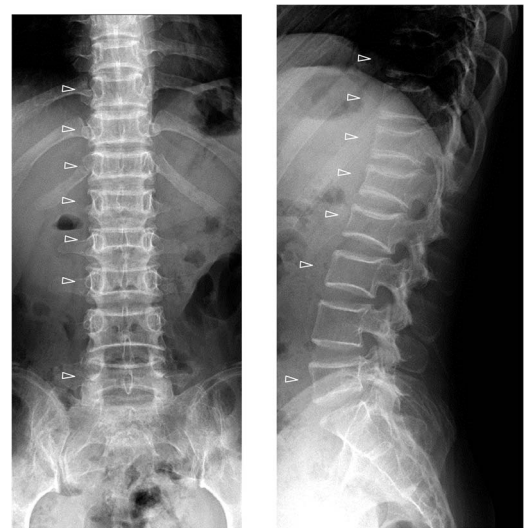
Radiography images obtained 55 months after the first fracture. Radiography shows recovery of the collapsed vertebral body height and ossification of the endplates.
